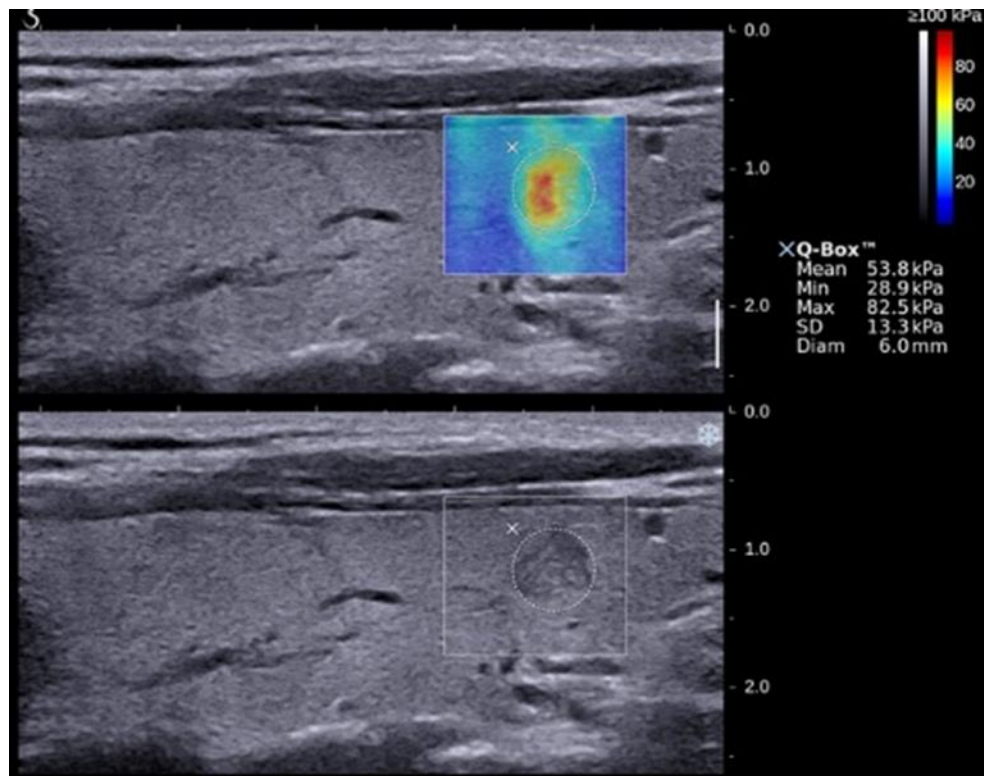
Longitudinal elastogram (upper) and grey-scale sonogram (lower) of a papillary carcinoma in the right thyroid lobe of a 57-year-old patient. The value of elasticity indices ( $E_{\text{maximum}} = 82.5 \text{ kPa}$  and  $E_{\text{mean}} = 53.8 \text{ kPa}$ ) were higher than the respective cut-off values reported in the present study.
